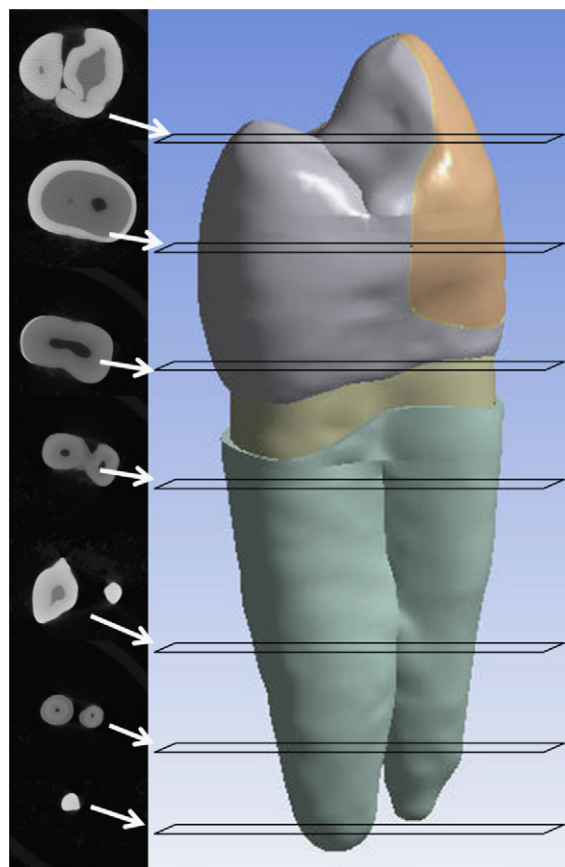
Tooth reconstructed in the SolidWorks software based in some slices obtained by using μ CT data (CT40, Scanco Medical, Bassersdorf, Switzerland).
